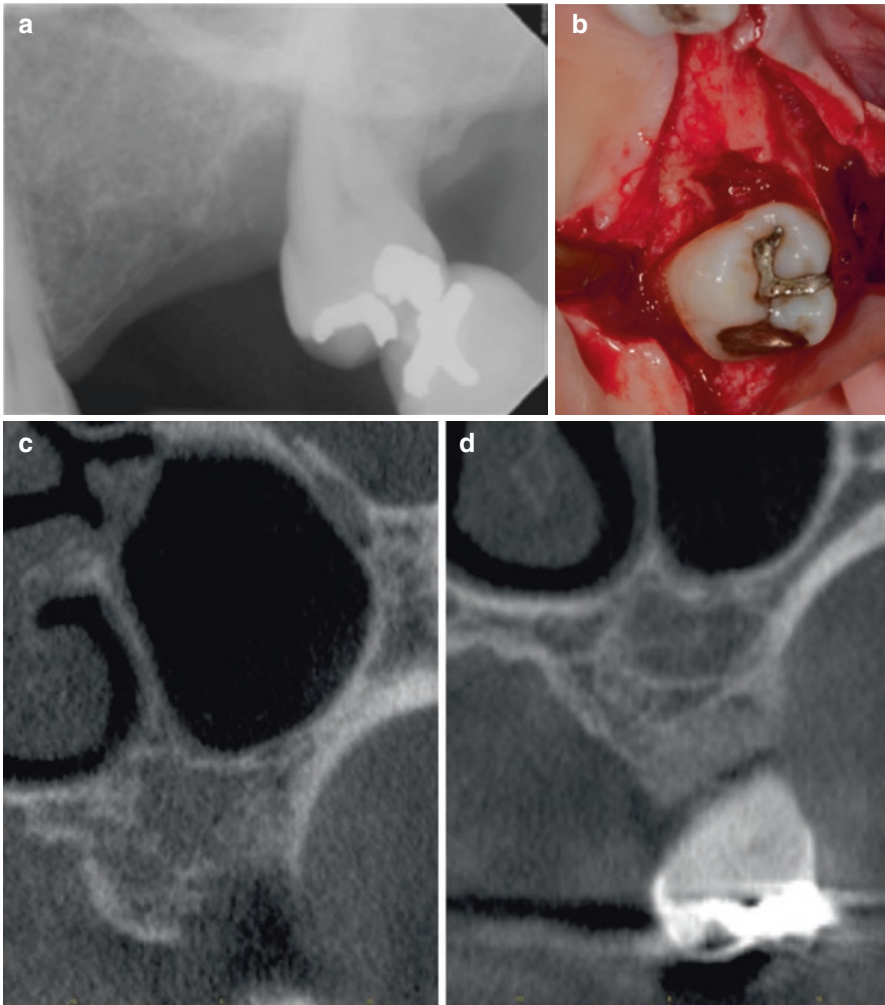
(a) Radiographic image of infrabony defect on the mesial of the maxillary left second molar. (b) Clinical photograph showing infrabony three-wall defect. (c) Presurgical CBCT image of defect. (d) Postsurgical CBCT image showing bone fill within the infrabony defect
